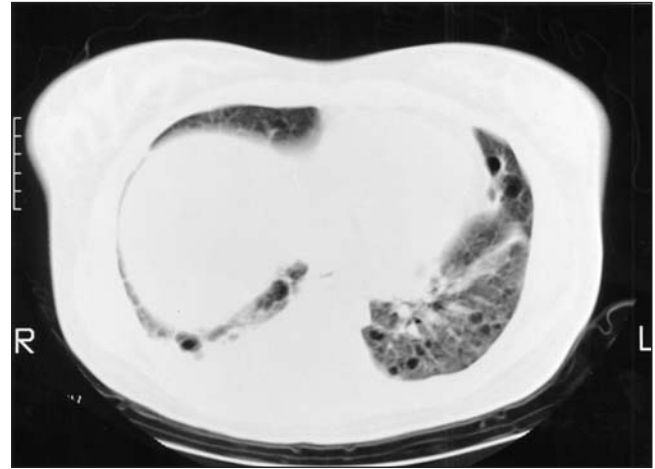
Lung cuts from an abdominal computed tomography scan performed in 1991. Multiple cysts are evident in the lung bases
